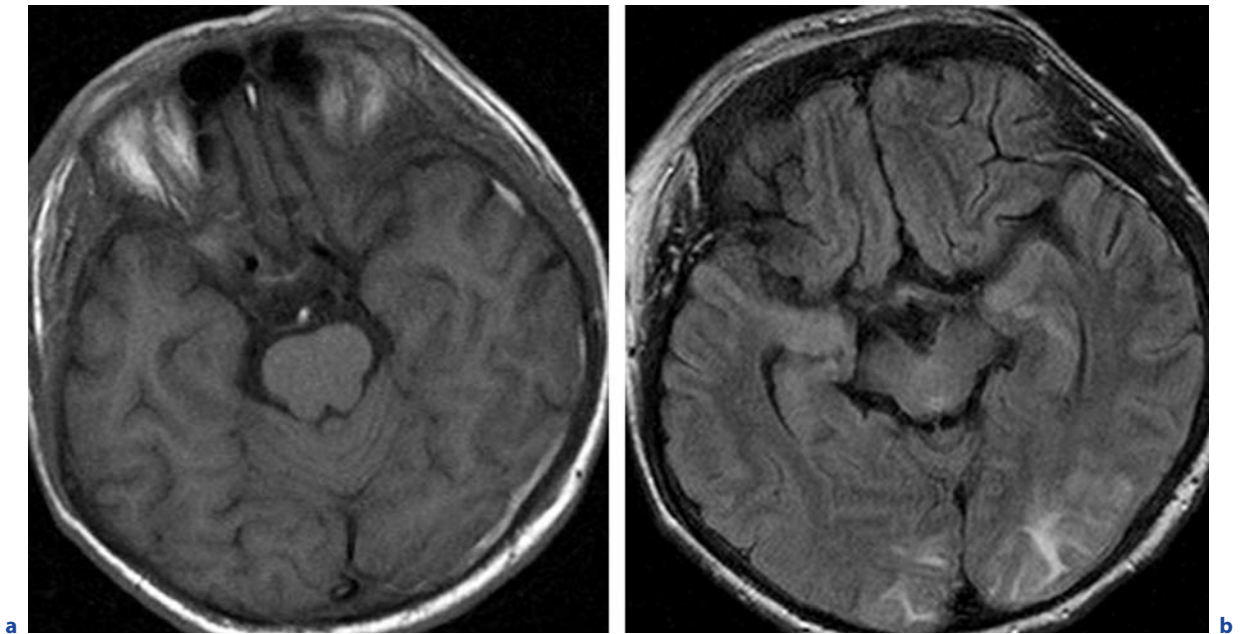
Viral vasculitis (*Varicella zoster*). A 37-year-old immunocompromised man with ophthalmic zoster presenting with alternating phases of reduced vigilance and severe agitation. In the CSF *Varicella* viruses were found (as confirmed by PCR). a Axial T1-weighted image. b Axial FLAIR image. Left
